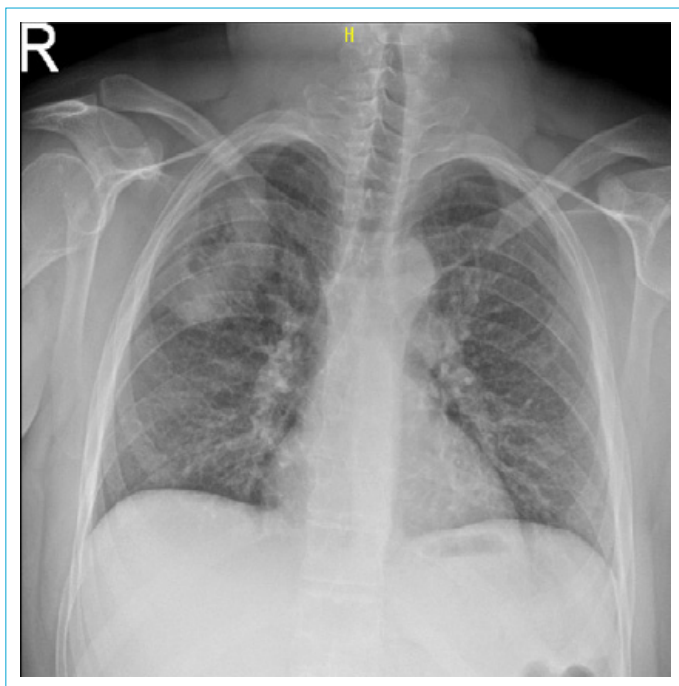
Posteroanterior chest radiography.
